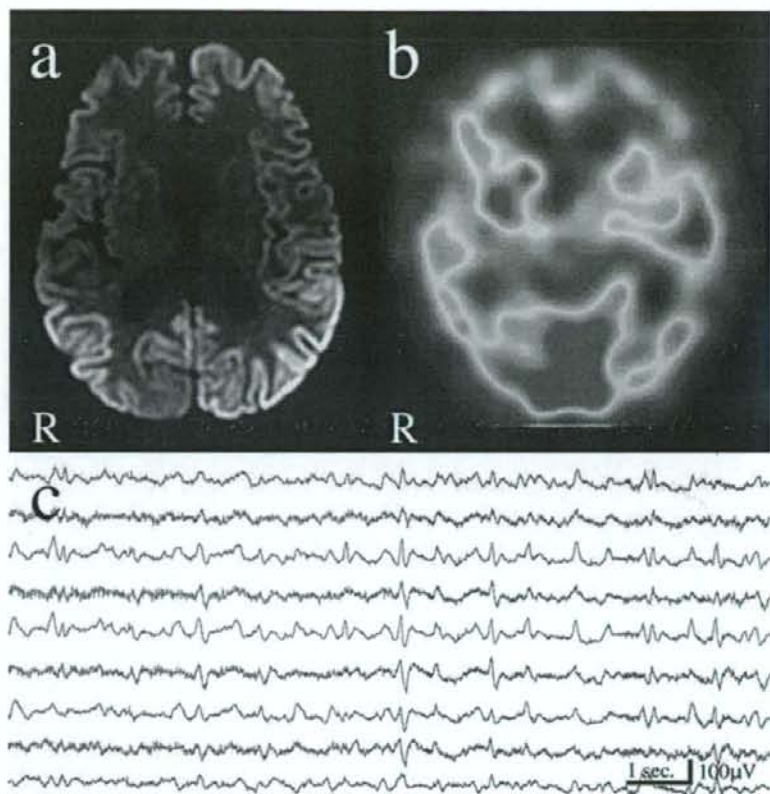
Diagnostic images. (a) MRI obtained 2 months after the onset of symptoms shows high signal-intensity lesions on diffusion-weighted images bilaterally in the frontal and occipital cortices (more so in the left occipital cortex). Ventricular dilatation is also apparent. (b) ^{99m}Tc -ethyl cysteinyl dimer single-photon emission CT scan obtained 3 months after the onset of symptoms shows moderate reduction of cerebral blood flow bilaterally in the frontal, parietal and occipital lobes (more so in the left parietal lobe). (c) Electroencephalogram obtained 3 months after the onset of symptoms shows slow-wave activity with periodic sharp-wave complexes. R, right side.
